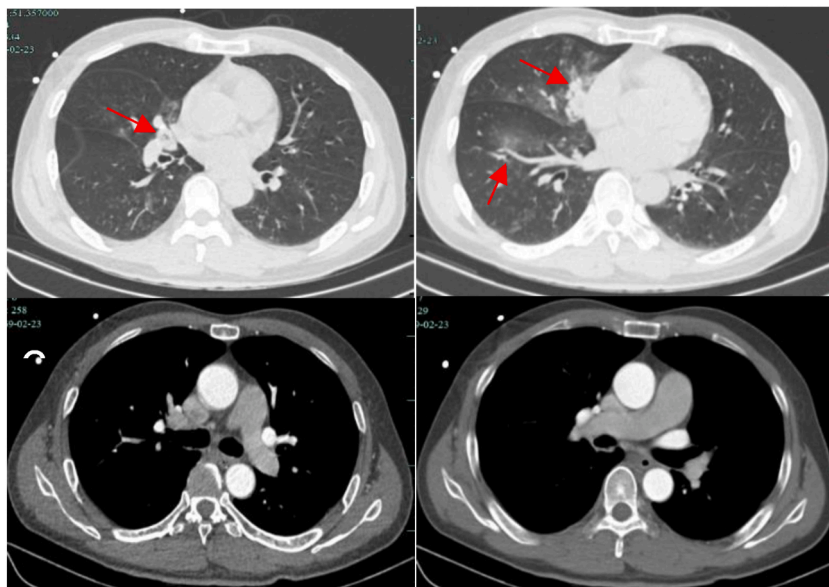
(A) CTA showed right middle bronchial obstruction on the day before admission (red arrow). (B) Obstructive pneumonia and alveolar hemorrhage can be seen in the right middle lobe. In addition, alveolar hemorrhage can be seen in the lower right lobe (red arrow). (C) CTA showed no abnormalities in the bronchial artery, pulmonary artery trunk, and left pulmonary artery. (D) CTA showed no abnormalities in the bronchial artery, pulmonary artery trunk, and right pulmonary artery.
